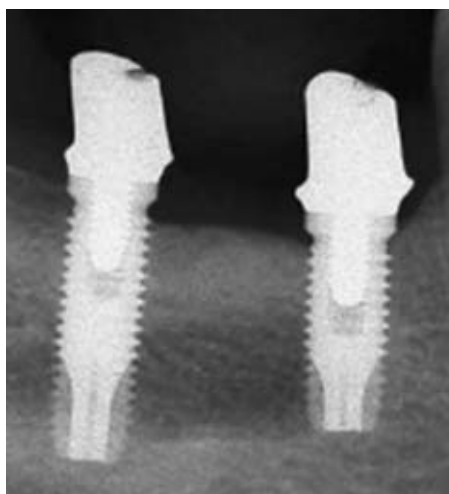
Intraoral radiograph taken at delivery of the provisional prosthesis.
